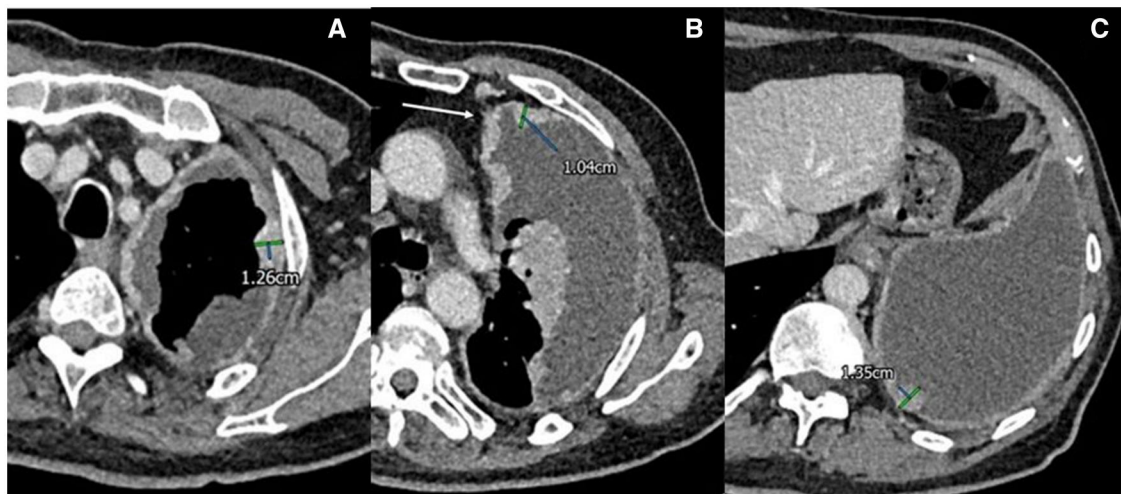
T3 tumour. A-C. T2 epithelioid mesothelioma, diagnosed via ultrasound guided pleural biopsy. There is a large left pleural effusion, with irregular circumferential pleural thickening. The images show P1 max measurement in the upper zone (A), P2 max measurement in the mid zone (B), P3 max measurement in the right lower zone (C) with a Psum measurement >30 mm. Fissural tumour cannot be assessed due to the significant lung collapse. B, Invasion into the mediastinal fat (white arrow), another T3 descriptor.
